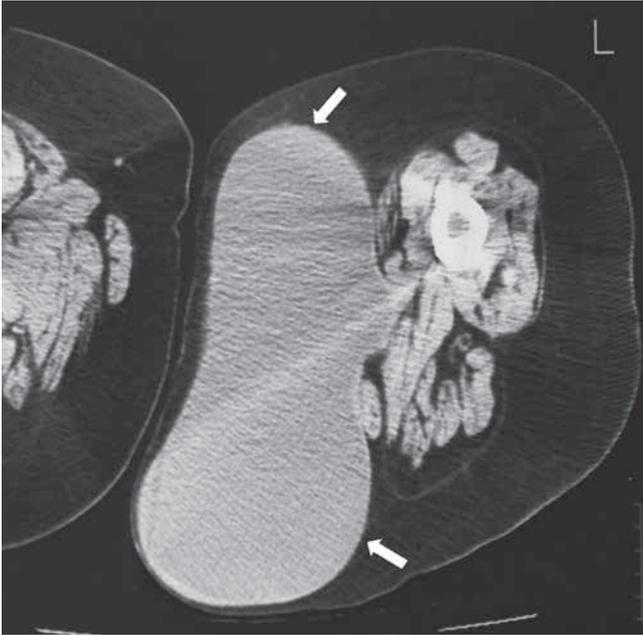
The CT scan of the left thigh in the axial plane showing a well-circumscribed unilocular giant cystic mass (arrows) originating from the adductor muscles and extending through the subcutaneous tissue. The cyst seems to have a narrow neck in the medial portion posterior to the vessels. Note that the bony structures are intact.
